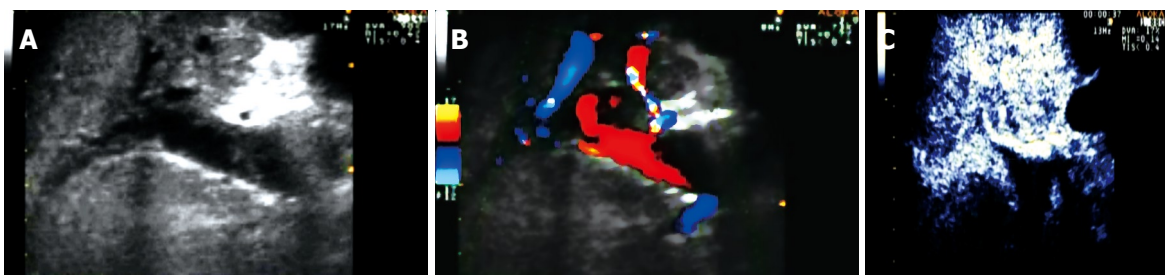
Benign thrombus. A: On sonography lumen of portal vein is partially filled with hypoechoic material representing occlusive thrombus; B: Color Doppler ultrasound reveals color signals only within a portion of portal lumen; C: Contrast-enhanced sonography scan during portal phase reveals uniformly non-enhancing area within portal vein, perfectly reproducing the benign thrombus.
